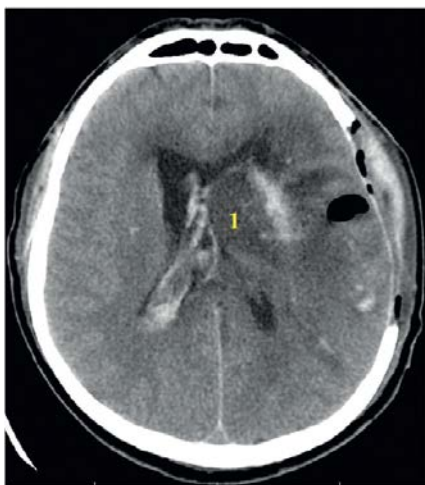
Multislice computed tomography of the brain on day 2 after the removal of intracerebral hematomas: 1 — residual hematoma, cerebral edema
